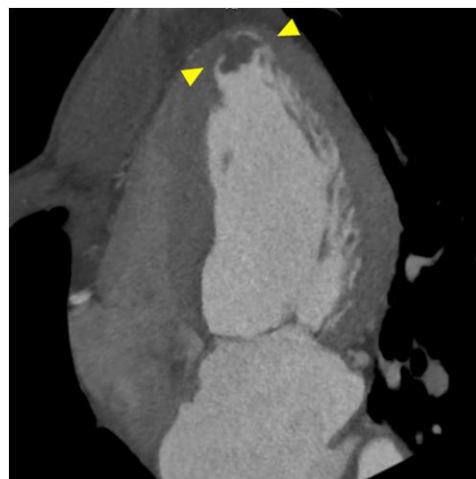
Left ventricular thrombosis detected by cardiac computed tomography. Cardiac computed tomography demonstrates left ventricular thrombus.
